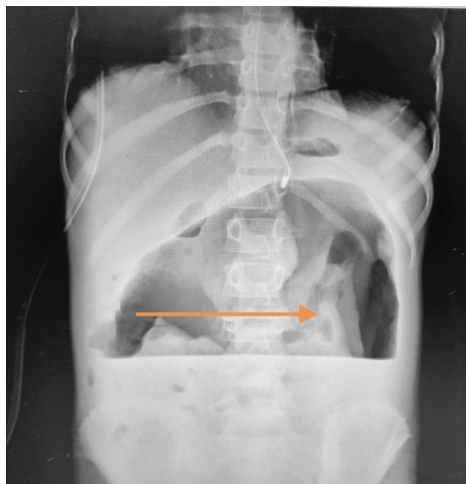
X-ray abdomen erect view showing air fluid level
